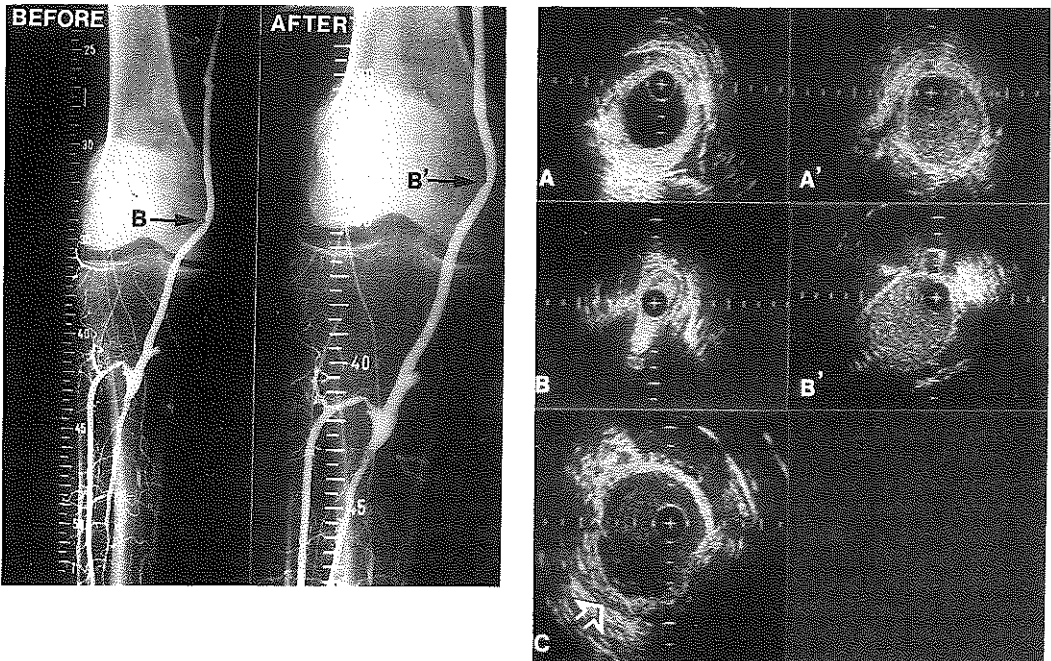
Angiograms and corresponding intravascular ultrasound cross-sections of a vein bypass graft before and after cleaving. Before cleaving a stenosis is seen at the level of the medial condyle of the knee (arrow B), that is no longer visible angiographically following cleaving (arrow B'). A and C, intravascular ultrasound reveals a patent bypass graft and anastomosis. B, local external compression of the bypass seen at level 34 changes the shape of the lumen to ellipsoid, whereas after cleaving, its normal circular shape is seen (B'). Note the effect of saline to clear the lumen from blood (compare A–A'). Open arrow: hypochoic media; calibration = 1 mm.
